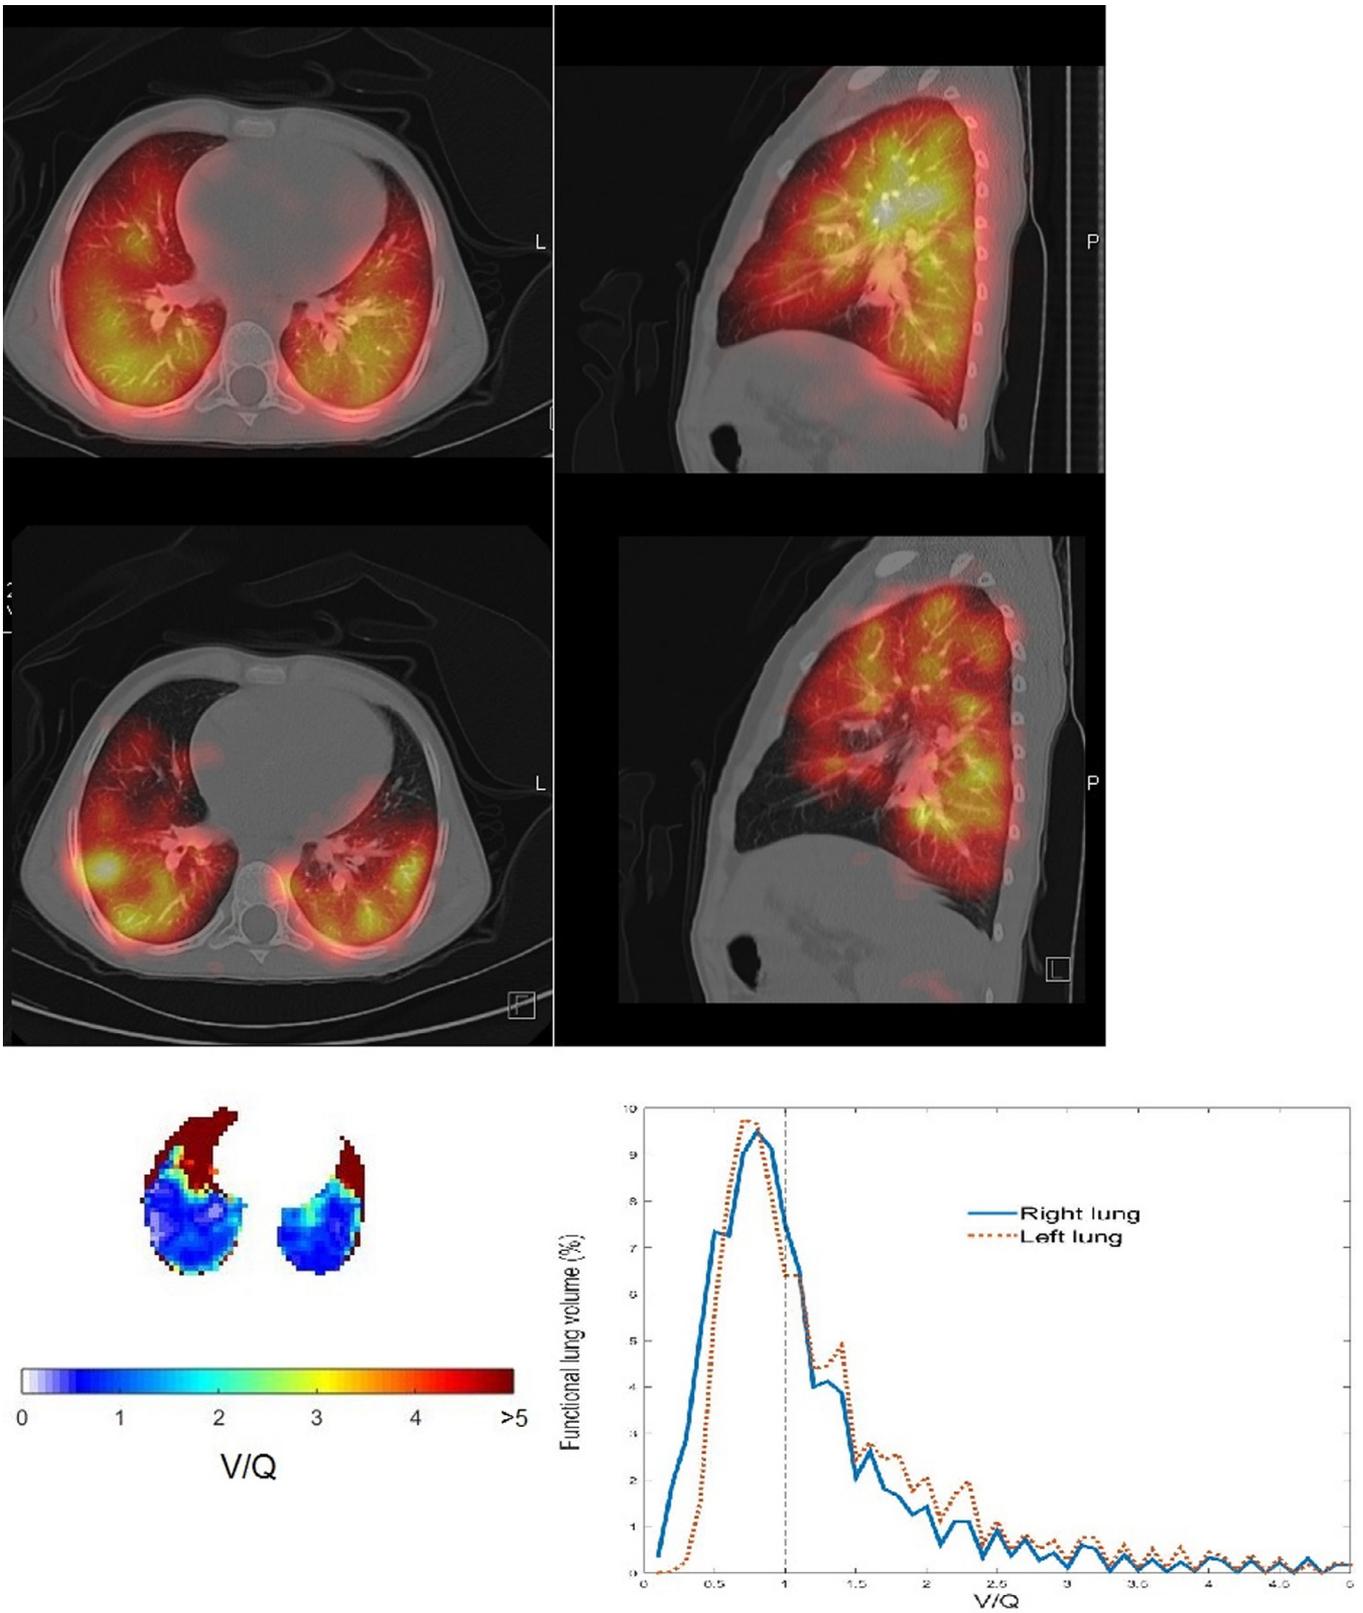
Pulmonary ventilation and perfusion fused SPECT/CT in a 7-year-old patient with pulmonary blood shunting. The first row represents the ventilation distribution in selected transversal and sagittal sections. The second row shows the corresponding perfusion distribution. The third row shows to the left, the corresponding V/Q ratio of the selected transversal section and to the right, the total lung functional V/Q ratio distribution.
